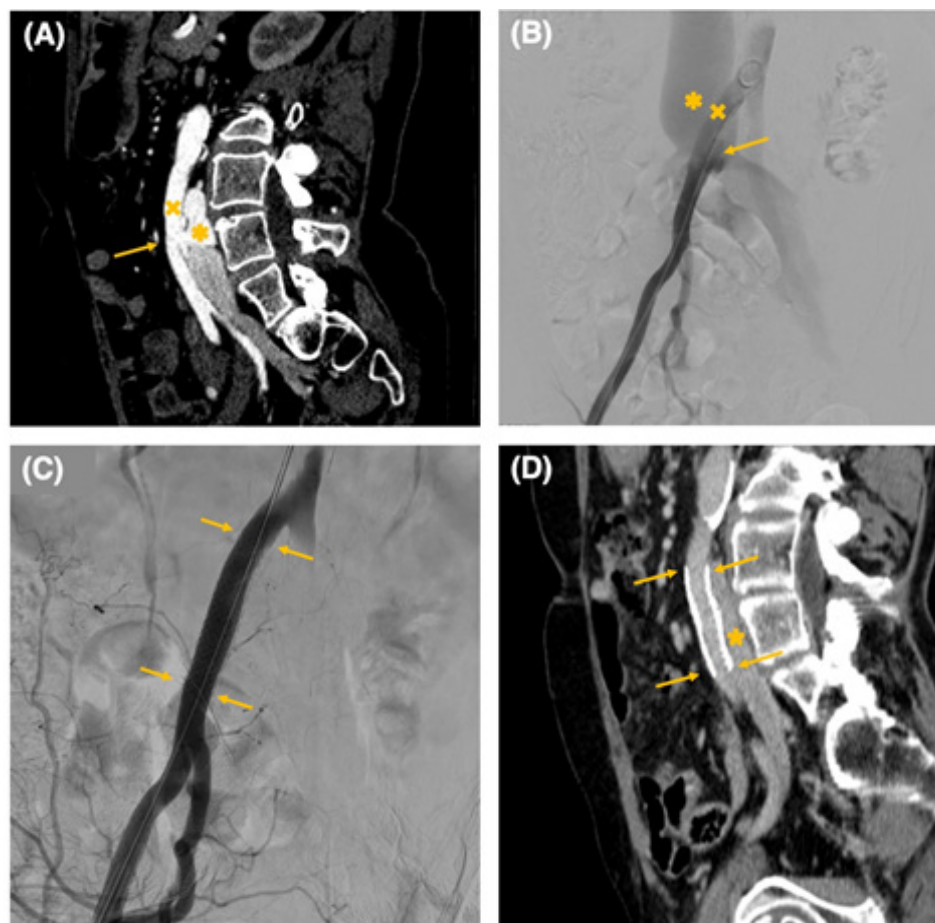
(A) Pre-procedural CT angiogram showing the fistulous communication (arrow) between the right common iliac artery and the inferior vena cava at the L3/L4 vertebral level. The right common iliac artery is marked (x), and early contrast opacification of the inferior vena cava through the fistulous tract is noted during the arterial phase (asterisk). (B) Pre-intervention angiography demonstrating the arteriovenous fistula (arrow), the right common iliac artery (x), and a markedly dilated inferior vena cava (asterisk). (C) Post-intervention angiography showing the covered metal stent in place (arrows). (D) Post-procedural CT angiogram confirming appropriate stent positioning (arrows) and normal opacification of the inferior vena cava, with no evidence of residual fistulous flow.
